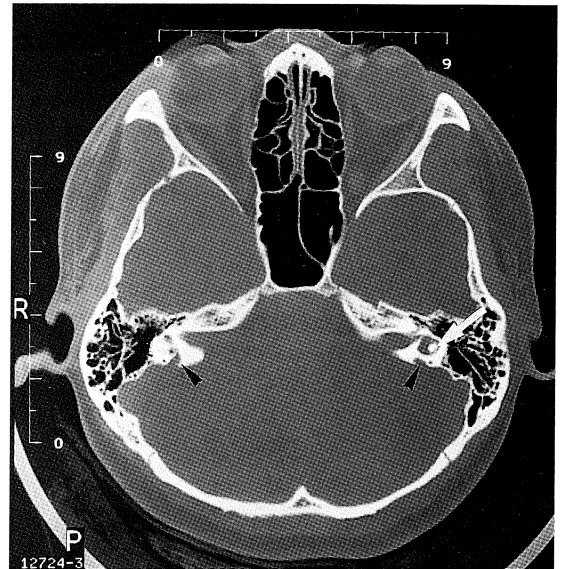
High resolution CT scan in the axial plane showing the enlarged vestibular aqueducts (arrowheads) on both sides. The white arrow points to the lateral semicircular canal.
